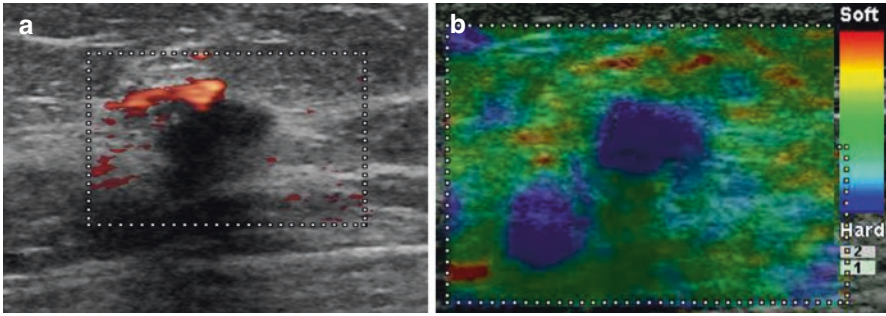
Noncalcified DCIS: power Doppler US image (a) demonstrates a hypoechoic mass with microlobulated and angular margins and antiparallel orientation and that is poorly vascularized. The lesion appears diffusely stiff on shear-wave elastographic image (b)
